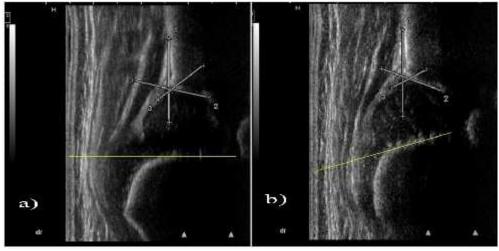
Standard ultrasound images of the same right hip. It can be seen the variation in the direction of the osteochondral plate - yellow line: a) horizontal; b) superior oblique. On the left side of the images are included the angles measurements.
